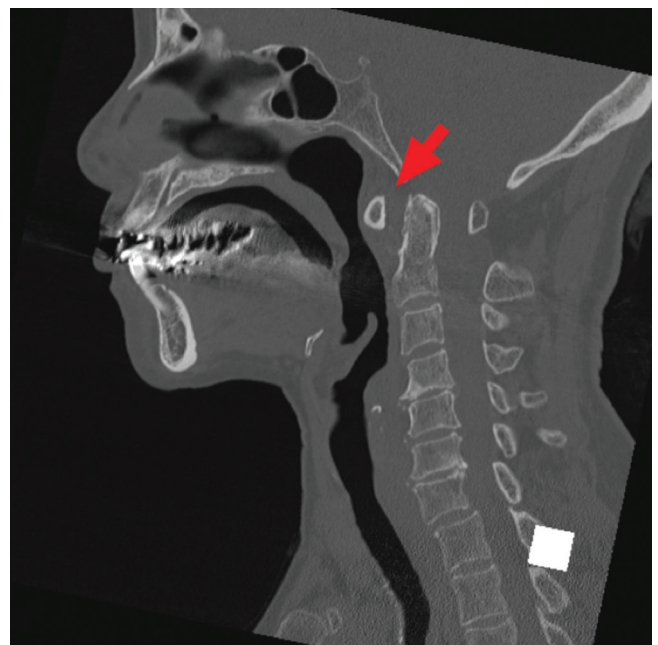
Abnormal atlantodental interval revealed by sagittal bone CT. CT: computed tomography.
